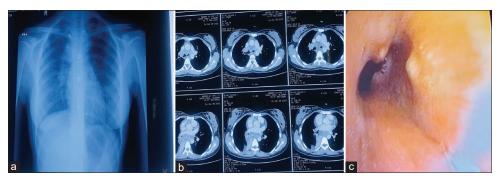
(a) Chest X-ray suggestive of right paratracheal opacity, (b) CECT thorax was suggestive of multiple enlarged conglomerating and necrotic mediastinal and jugular lymph nodes with sub-segmental collapse of posterobasal and medial basal segments of the right lower lobe, (c) bronchoscopic image showing nodular growth in the left main bronchus
